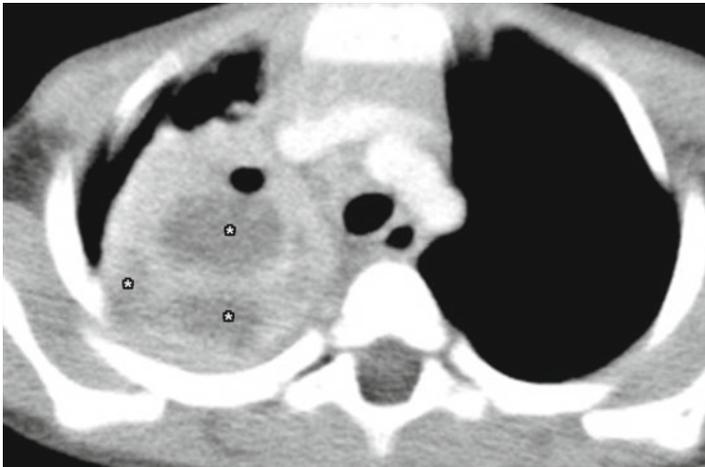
Pneumonia. CT. Axial CT image performed after intravenous contrast administration. Note a right upper lobe air space opacification with nonenhancing areas (*asterisks*) and an air fluid level representing necrotizing pneumonia
